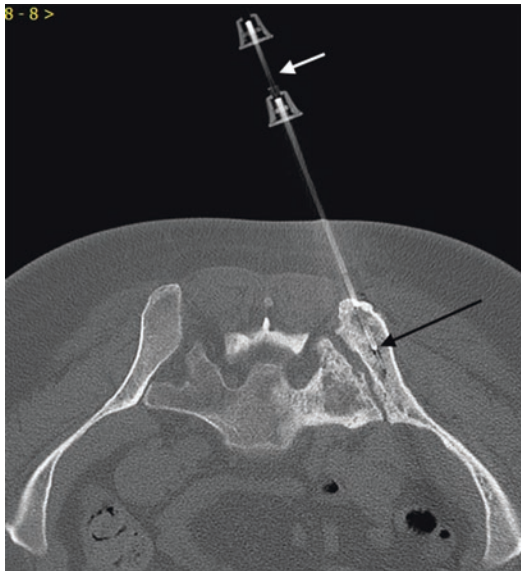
A 51-year-old female with lower low back pain. Axial CT image obtained during biopsy procedure shows sampling of a sclerotic lesion within the iliac crest (large arrow) with a coaxial bone biopsy needle system (short arrow). This iliac crest was biopsied instead of the sclerotic lesion within the adjacent sacral ala in this patient with breast metastases
